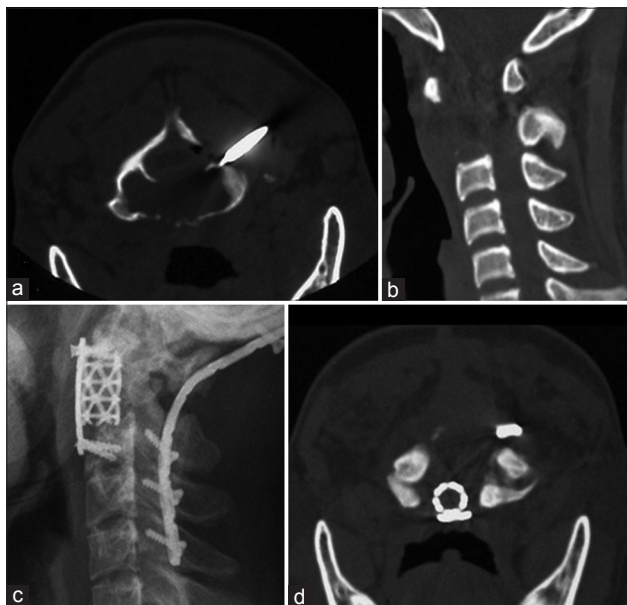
A 20-year-old male presented with a C2 giant cell tumor, treated through intralesional curettage in 2008. (a) CT-guided percutaneous biopsy. (b) Preoperative CT scan. (c and d) Lateral radiograph and axial CT image showing local recurrence at the 3-year follow-up, respectively. CT: Computed tomography.
